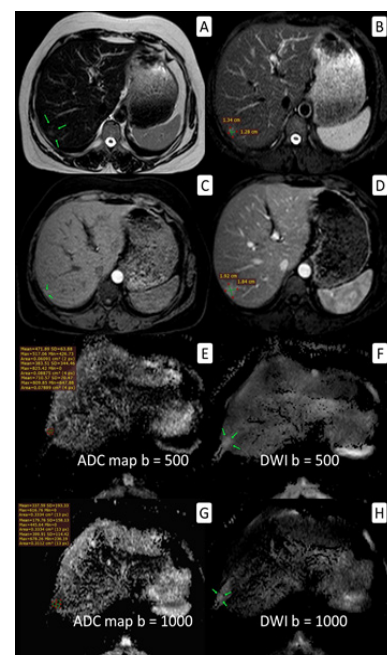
MRI Evaluation of a Benign Atypical Hemangioma in the Right Hepatic Lobe of a 41-year-old Female Patient. T2-weighted images (A, B) and dynamic contrast-enhanced T1-weighted images during arterial and portal venous phases (C, D) demonstrate the characteristic peripheral nodular enhancement pattern. Diffusion-weighted imaging and apparent diffusion coefficient (ADC) maps obtained at b = 500 and 1000 s/mm² are shown in panels E–H. ADC measurements were performed using manually placed regions of interest on ADC maps to quantify diffusion characteristics of the lesion.
